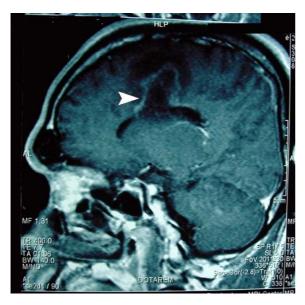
Sagittal T1-weighted MR image shows large hyposignal intensity lesion in frontal regions extended to the lateral ventricle but not extended to the cortex
